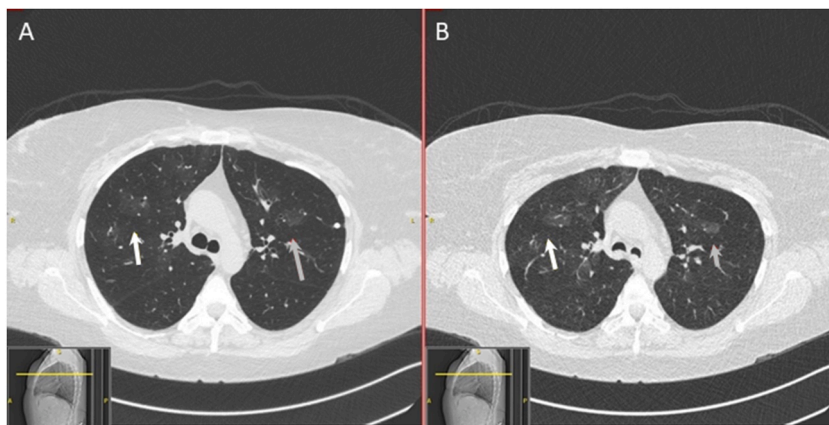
High-Resolution Computed Tomography Scan of the Thorax. A, An inspiratory image shows areas of mosaic, heterogeneous attenuation. The arrows denote areas of hypoattenuation with surrounding hyperattenuation. B, An expiratory image shows airtrapping with more prominent hyperattenuated areas (normal lung).
